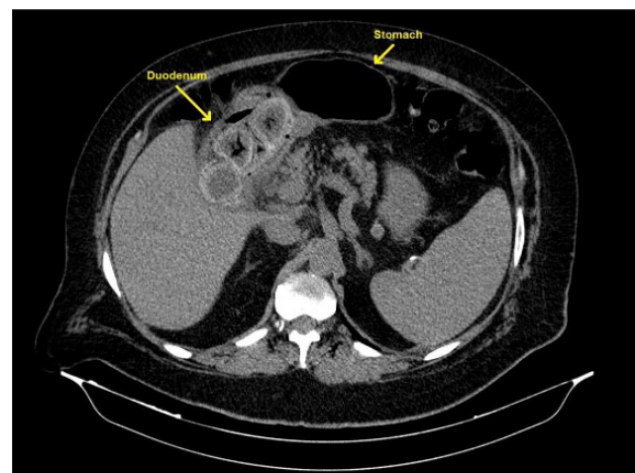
Unenhanced axial CT slice showing large gallstones impacted in the duodenum, causing gastric outlet obstruction (Bouveret syndrome). The gallbladder was contracted, suggesting that a cholecystoduodenal fistula had been formed, from which the stones passed to the duodenum.
